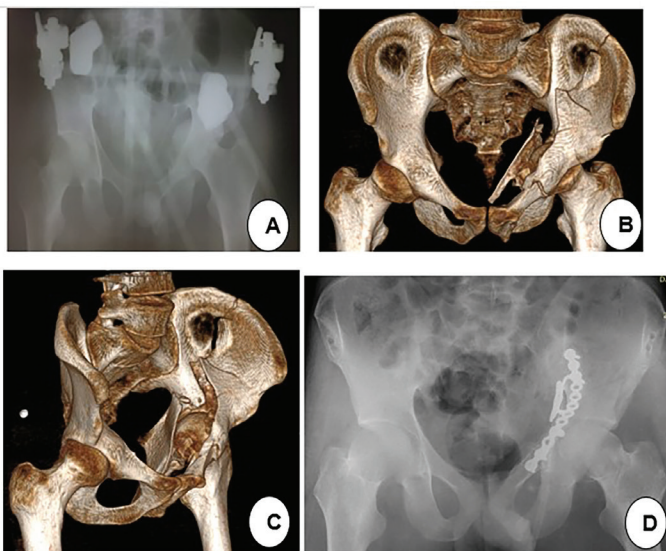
A 26-year-old patient with a both column fracture of the acetabulum. Preoperative x-ray and CT sections: A) preoperative direct x-ray, B,C) preoperative CT sections, D) X-ray on postoperative day 1.
